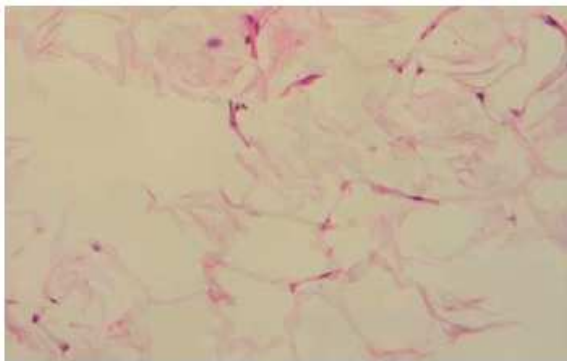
Sample infiltrated with Aqualyx® and subsequently exposed to external ultrasound: swollen adipocytes and "split rail" separation of the cellular membrane lipidic bilayer, homogenised cytoplasm content and widespread area of cellular destruction.
